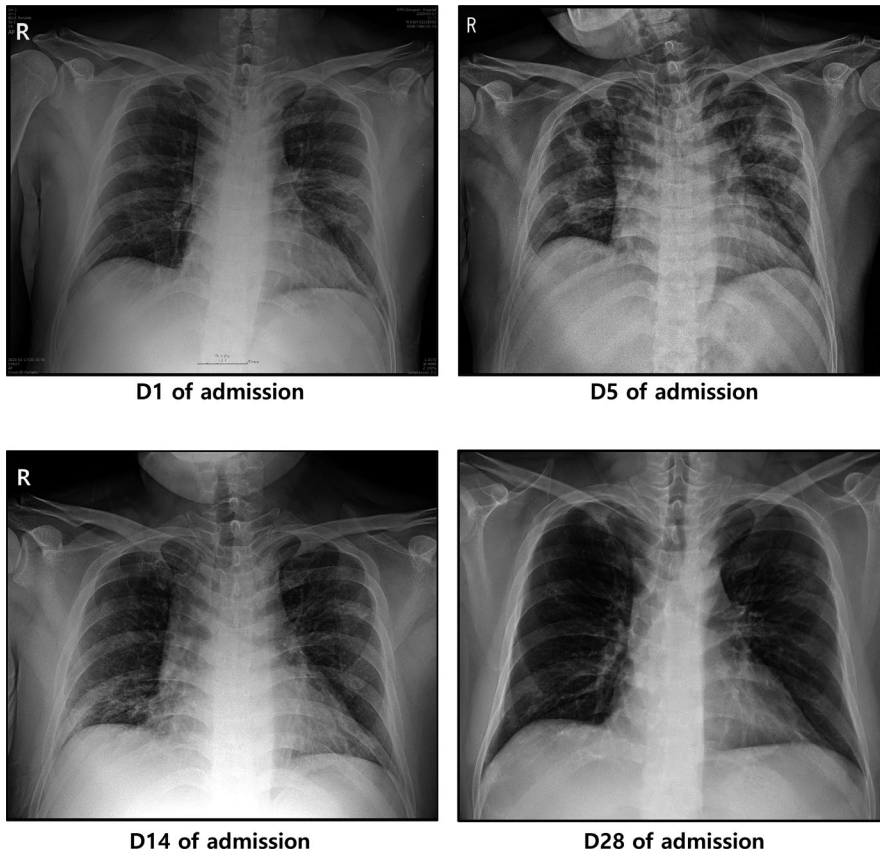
Changes in chest radiograph findings in Case 1. The admission date was represented as day 1 (D1). The infiltrative lesion was aggravated on D5. It started to improve from D14 and further improved on D28
